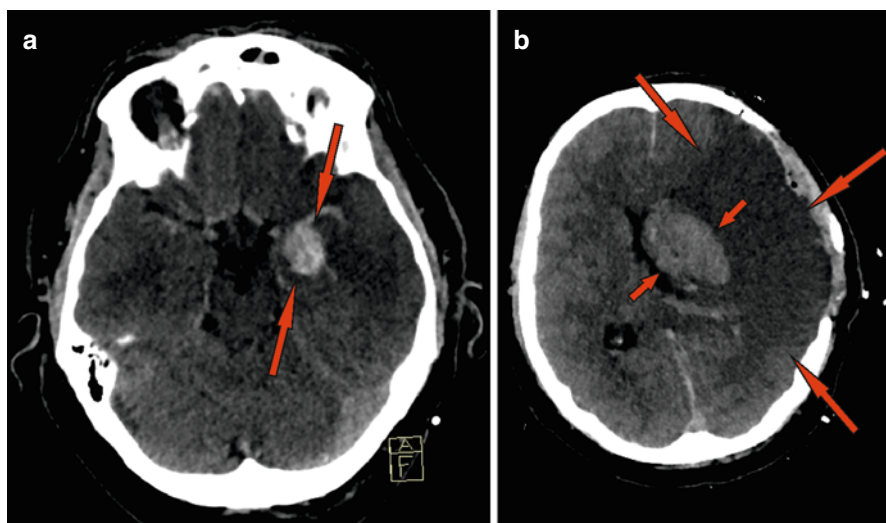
CT scan of the haemorrhage transformation of acute ischaemic stroke following thrombolytic therapy. Imaging following 4 h thrombolytic systemic treatment (a) – intracranial haematoma (*red arrows*). CT imaging in the same patient 21 h after thrombolytic therapy (b) demonstrating intracranial haematoma (*short arrows*) and a wide area of ischaemic infarction (*long red arrows*)
